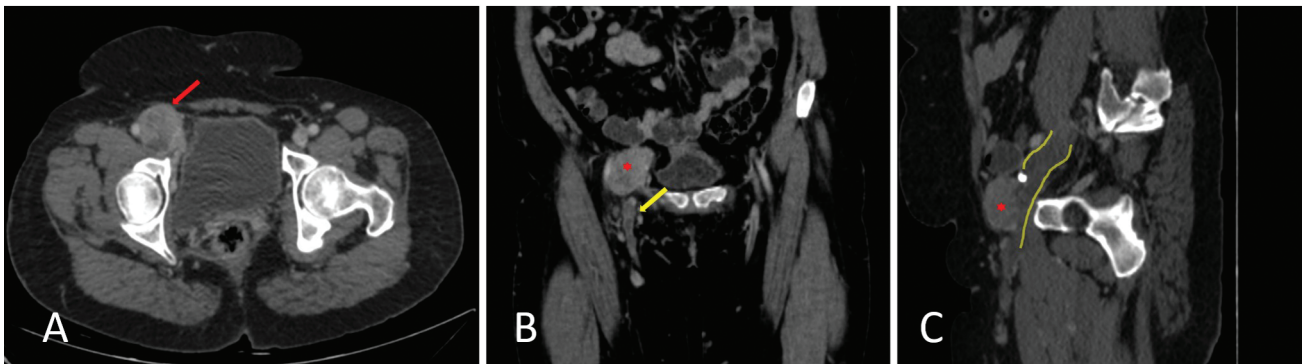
(A) Axial contrast-enhanced computed tomography (CT) image showing enhancing mass (green arrow) likely arising from the anterior wall of the common femoral vein which is also showing a nonenhancing thrombus within the lumen. (B) Coronal image showing the mass (red asterisk) and a nodular enhancing filling defect in the great saphenous vein (yellow arrow). (C) Sagittal image showing the mass (red asterisk) with a focal calcification with intravenous extension to common femoral vein. The femoral and external iliac vein (yellow outline) filled with nonenhancing bland thrombus.
